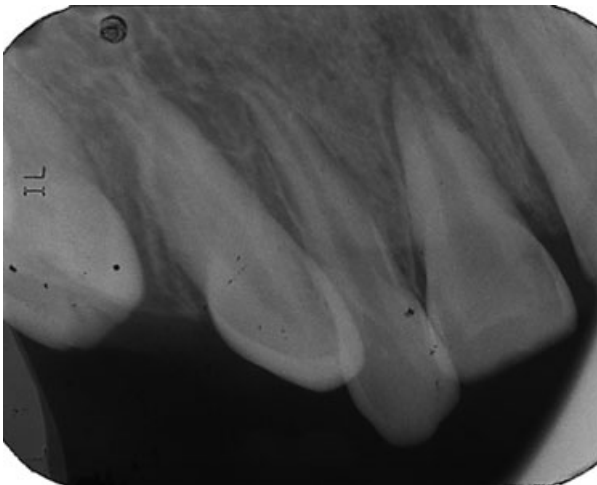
Preoperative radiographic view.
